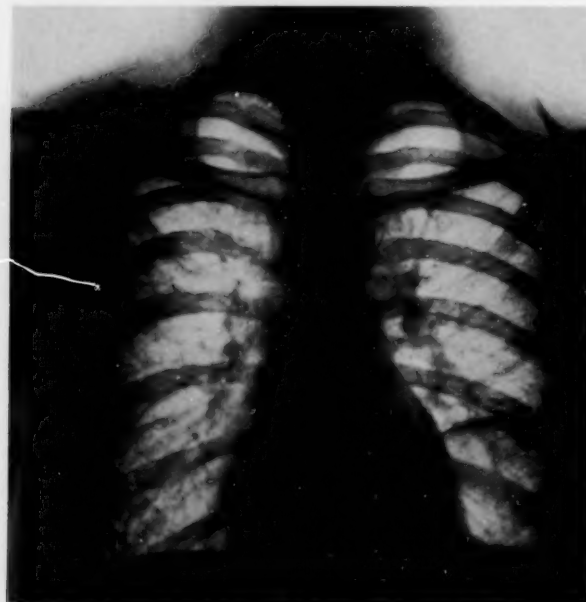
Anterior-posterior roentgenogram made eight months after operation for repair of diaphragmatic hernia. Note that the recurrent hernia has greatly increased in size. The effect of the phrenic-nerve crushing had now disappeared, as the hernial sac descended 1 centimetre on deep inspiration, and the faintly visible edges of the separated diaphragmatic muscle moved 2.1 centimetres.
